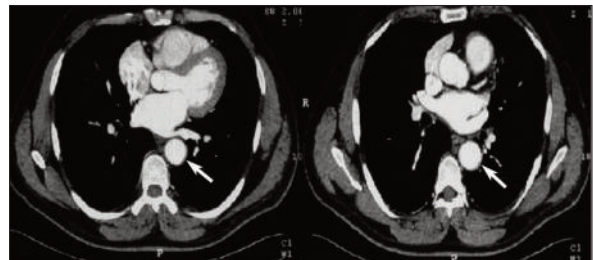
CT images showing completely resolved intramural hematoma at the two year follow-up.
